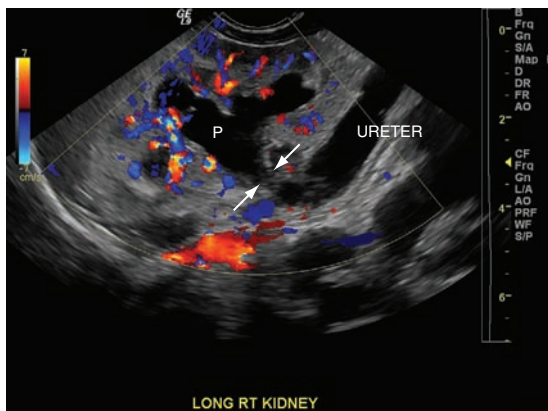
Hydronephrosis with hydroureter. Longitudinal sonogram showing dilated renal pelvis (P) and dilated tortuous proximal and mid ureter. Echoes arising from scanning artifacts (arrows) are seen due to tortuosity of the ureter.
